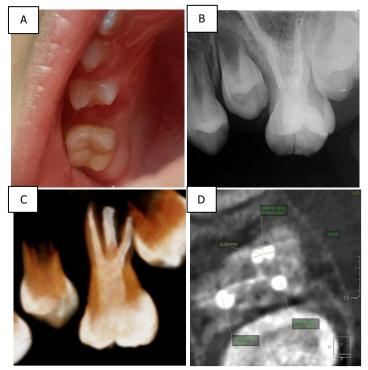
3rd Follow-up; A. clinical view of 3rd months follow-up B. radiograph view of 3rd months follow-up, C. cbct (3d buccal view), D. cbct (axial view)
